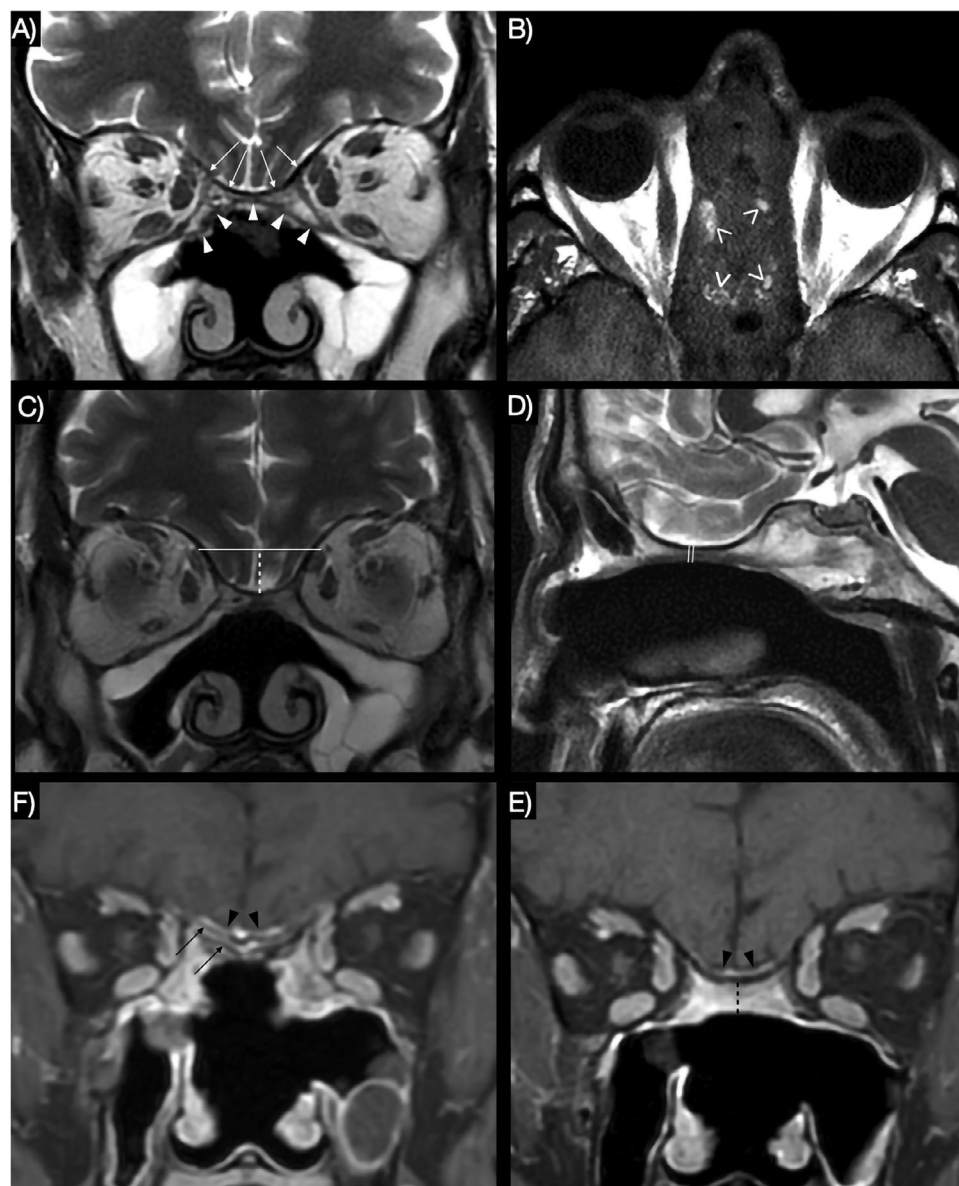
Radiological features evaluated on post-operative MRI. In (A) the first and second layers of the iliotibial tract are visible and appear on this T2-weighted sequence as a hypointense intracranial layer (white arrows). The third layer is also identifiable, showing a hypointense signal on T2-weighted imaging and an extracranial location (white arrowheads). In (B), adipose tissue is visible on T1-weighted imaging, where it appears hyperintense and shows signal loss on fat-suppressed sequences. In (C), the brain sagging (white dotted line) is evaluated in the coronal plane passing through the origin of the optic nerves, using as a reference the line tangent to the upper margins of the superior oblique muscles (white line). (D) Minimum thickness of the ASB reconstruction, measured on the sagittal plane (white lines). Finally, a comparison is shown between MRI performed at 3 months after surgery (E) and at 12 months (F). In both examinations, contrast enhancement is observed on the dural side of the first layer (black arrowheads). However, on the 3-month MRI, the first and second layers are still distinguishable (black arrows) and no enhancing endonasal tissue is present. In contrast, on the 12-month MRI, enhancing endonasal tissue is visible (black dotted line), indicating that the skull base is undergoing or has completed the process of revascularization of the reconstructive graft.
